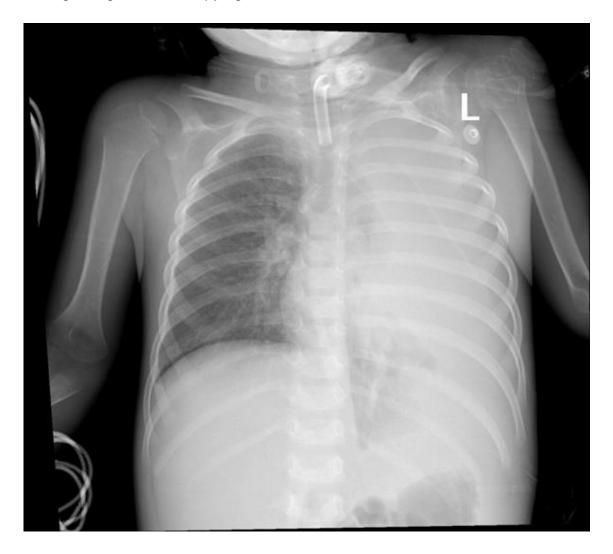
Chest X-ray of the 3-year-old child (supine view CXR) showing a huge mass on the left side of his chest.
